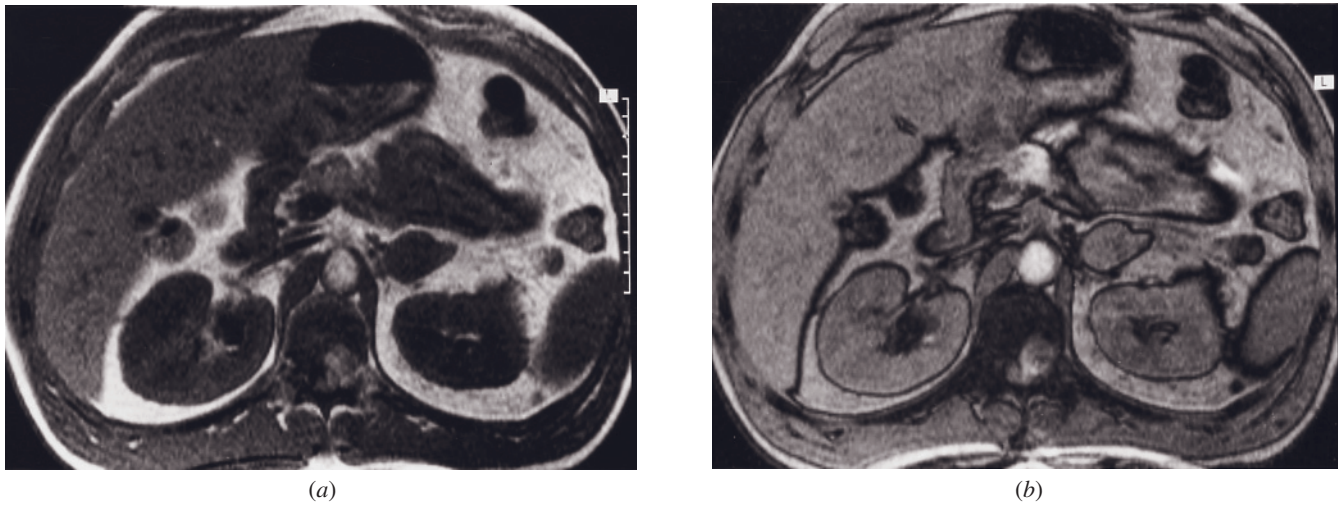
Adrenal adenoma—no signal drop. T1-weighted GE (a) and T1-weighted out-of-phase GE (b) images. No signal intensity drop is noted from in-phase (a) to out-of-phase (b) images. The lack of signal intensity drop reflects no appreciable intra-cytoplasmic lipid.
